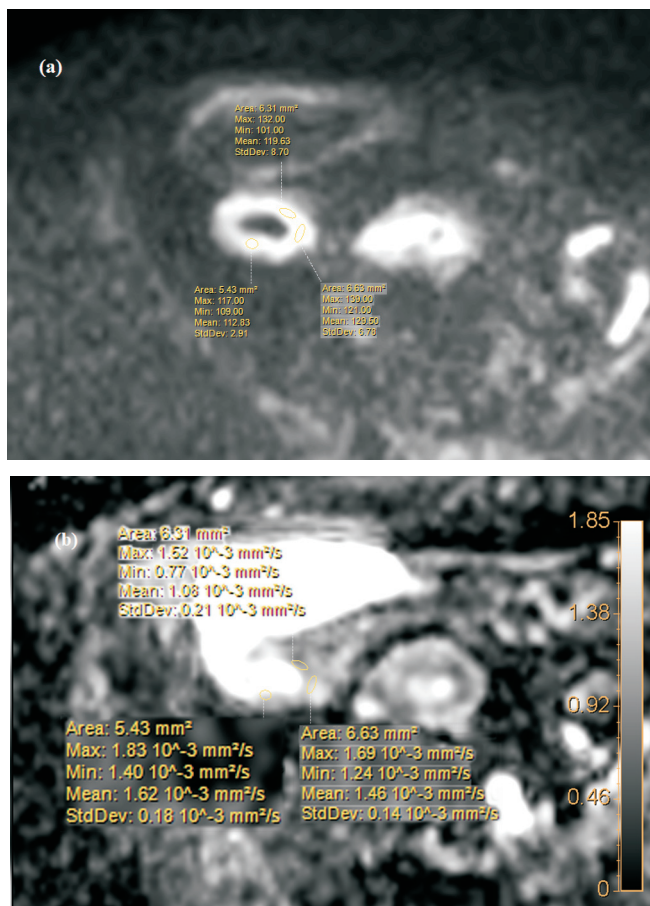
Selecting the ROI in STIR-based DWI images of 56 y.o. female ($b = 800$ s/mm²) (a). On the corresponding ADC map (b), the chosen ROI appears automatically.
